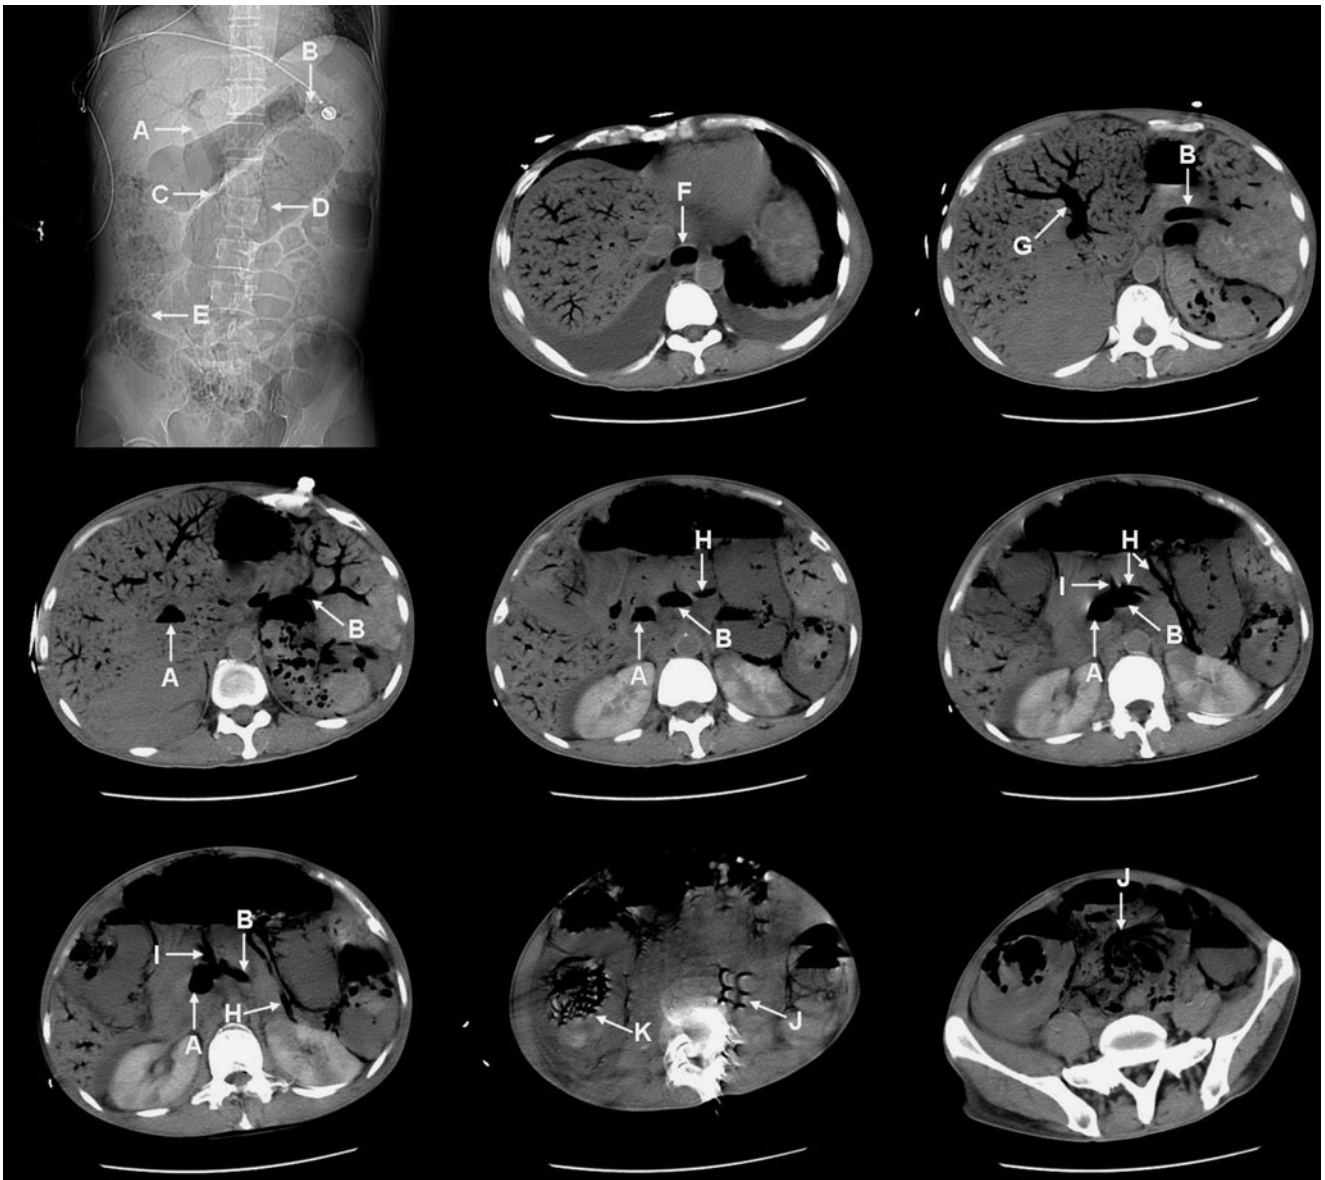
Gas in inferior vena cava, portal venous system, and pneumatosis intestinalis. Radiography of the abdomen reveals gas in portal vein trunk (*A*), splenic vein (*B*), superior mesenteric vein (*C*), inferior mesenteric vein (*D*), and diffuse intestinalis pneumatosis (*E*). Computed tomography shows frazil slush pattern change in liver, gas
